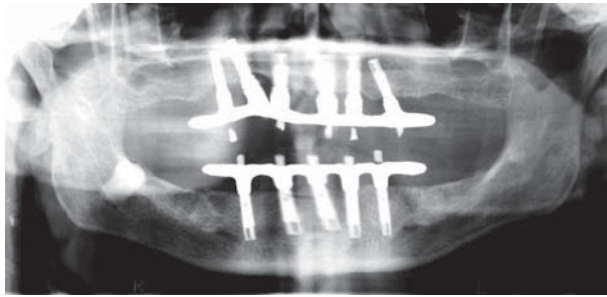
Panoramic radiograph after 1 year of function, showing five implants loaded after 10 days in the mandible. The six maxillary implants were placed more than 10 years before and are conventional Brånemark System™ implants.
